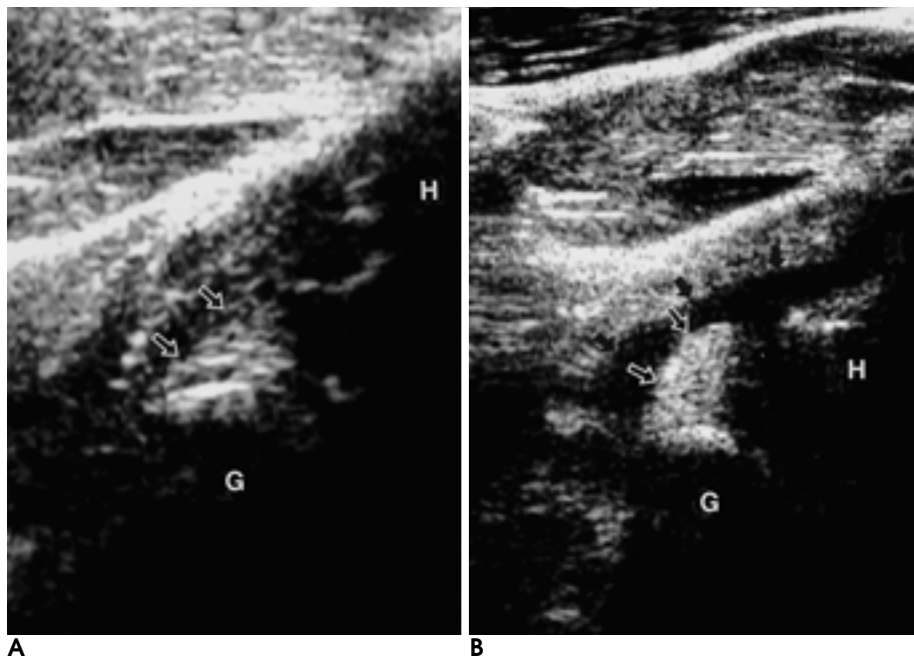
23-year-old man with left shoulder pain. Arthrosonographic effect for visualization of the glenoid labrum. G = glenoid, H = humerus.
